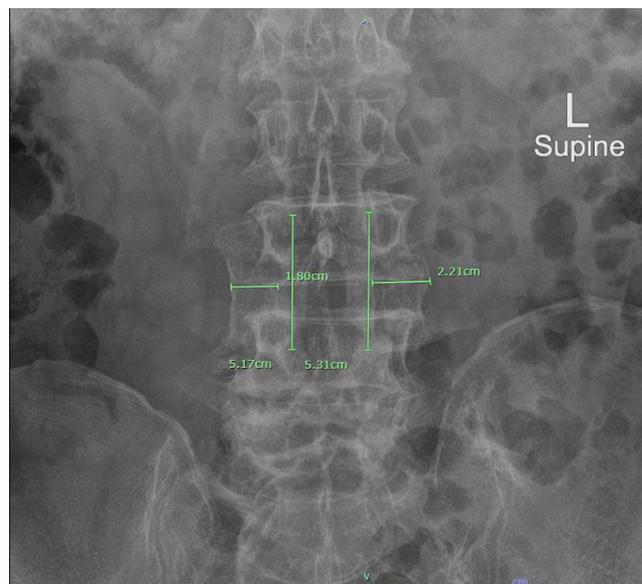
Demonstration of radiographic measurement
